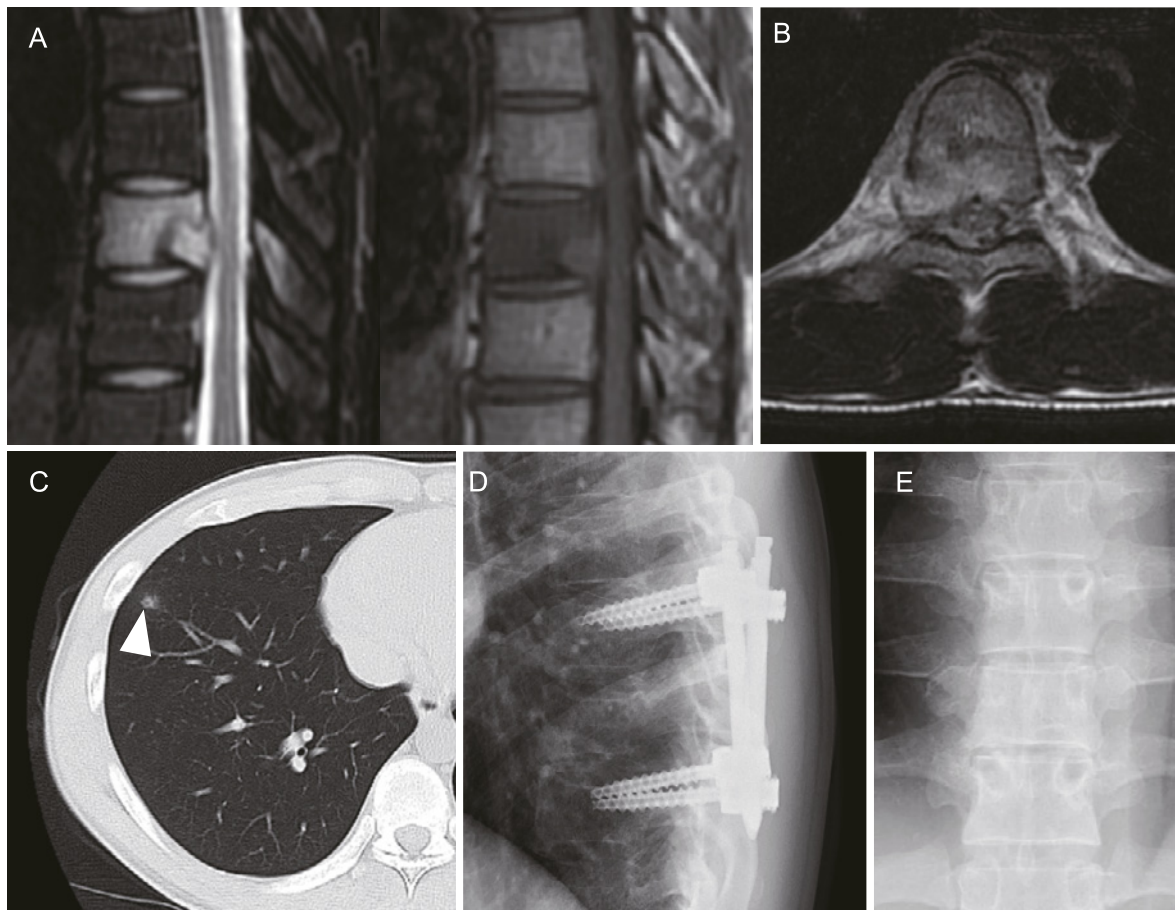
Imaging study of Case 2. A, Fat suppression T2-weighted (left) and T1-weighted (right) magnetic resonance imaging (MRI) showing an abnormal lesion in the T5 vertebra of Case 2. B, Fat suppression T2-weighted axial MRI revealing perivertebral and epidural lesions. C, A small nodule observed in the right lung. D, X-ray taken after the fixation surgery, showing the postoperative status. E, Postoperative X-ray taken 2 years later, after the removal of the instrumentation.
